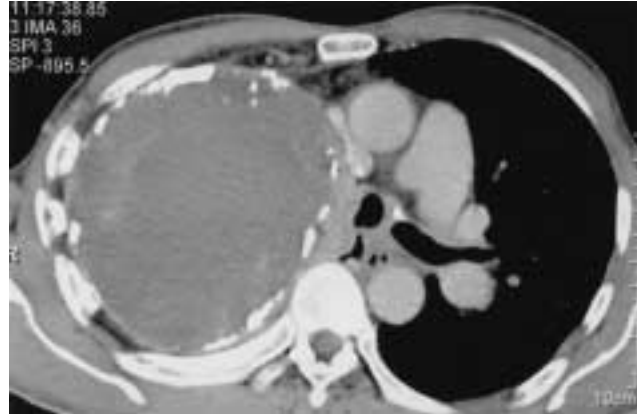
CT scan showing a large circumscribed mass occupying the entire hemithorax with calcification within, causing lung collapse.
